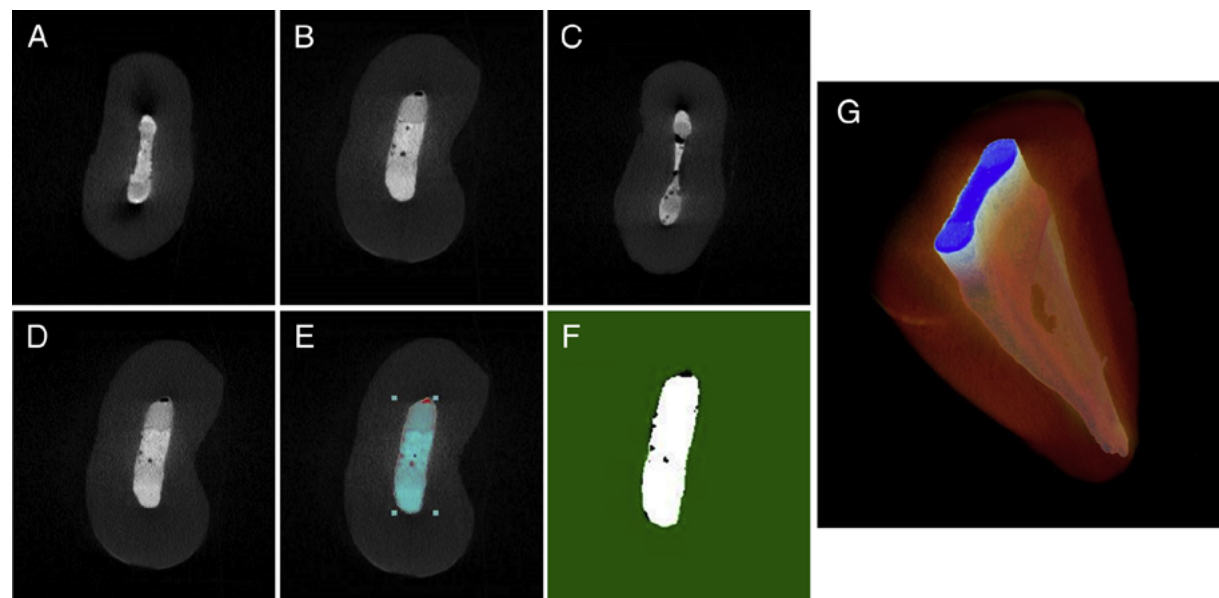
Representative micro-computed tomography images showing (A) no void, (B–D) marked defects, (E) region of interest (ROI) selection on images, and (F) void detection within the ROI. (G) Three-dimensional reconstructed models of the obturated root canals.
